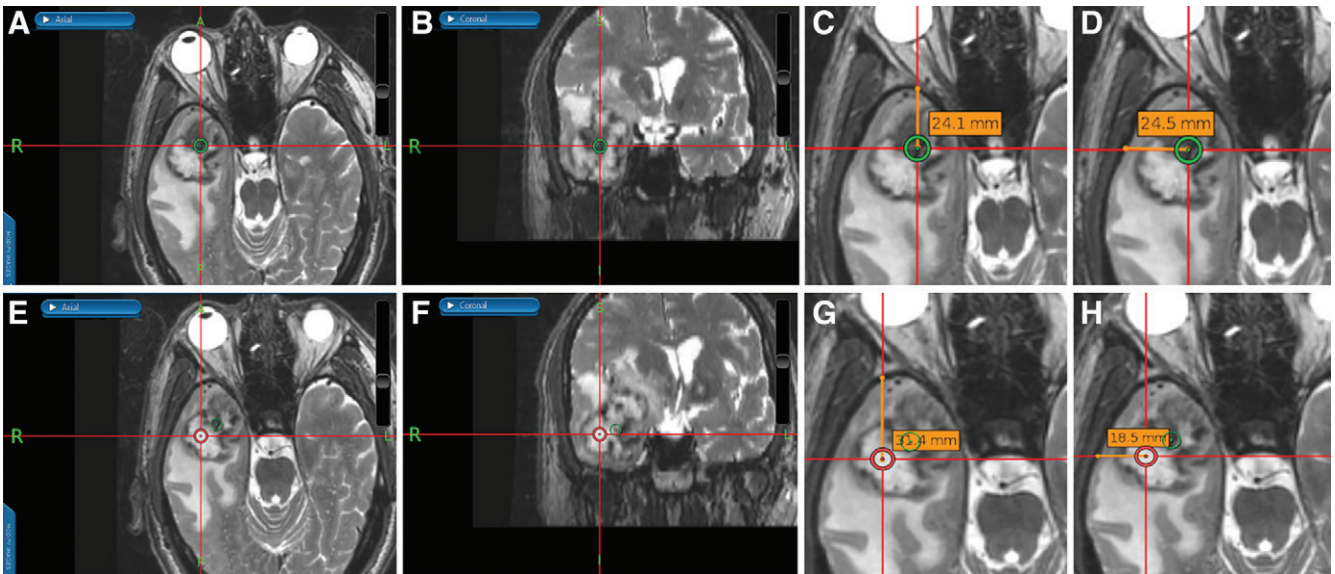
Images from an intraoperative surgical navigation system in a 74-year-old male participant with right temporal gliosarcoma. Stereotactic ferumoxytol-enhanced, *A*, axial and *B*, coronal thin-section T2-weighted images show a site of strong ferumoxytol-induced signal change (low signal) within the tumor that was chosen for sampling, as denoted by the green circle. *C*, *D*, *G*, *H*, During surgery, measured perpendicular lines were drawn from the center of the target region of interest (ROI) to the calvarium for localization of the ROI during image analysis. Stereotactic ferumoxytol-enhanced, *E*, axial and *F*, coronal thin-section T2-weighted images show a site of weak ferumoxytol-induced signal change (high signal) within the same tumor, as denoted by the red circle, that was also sampled.
